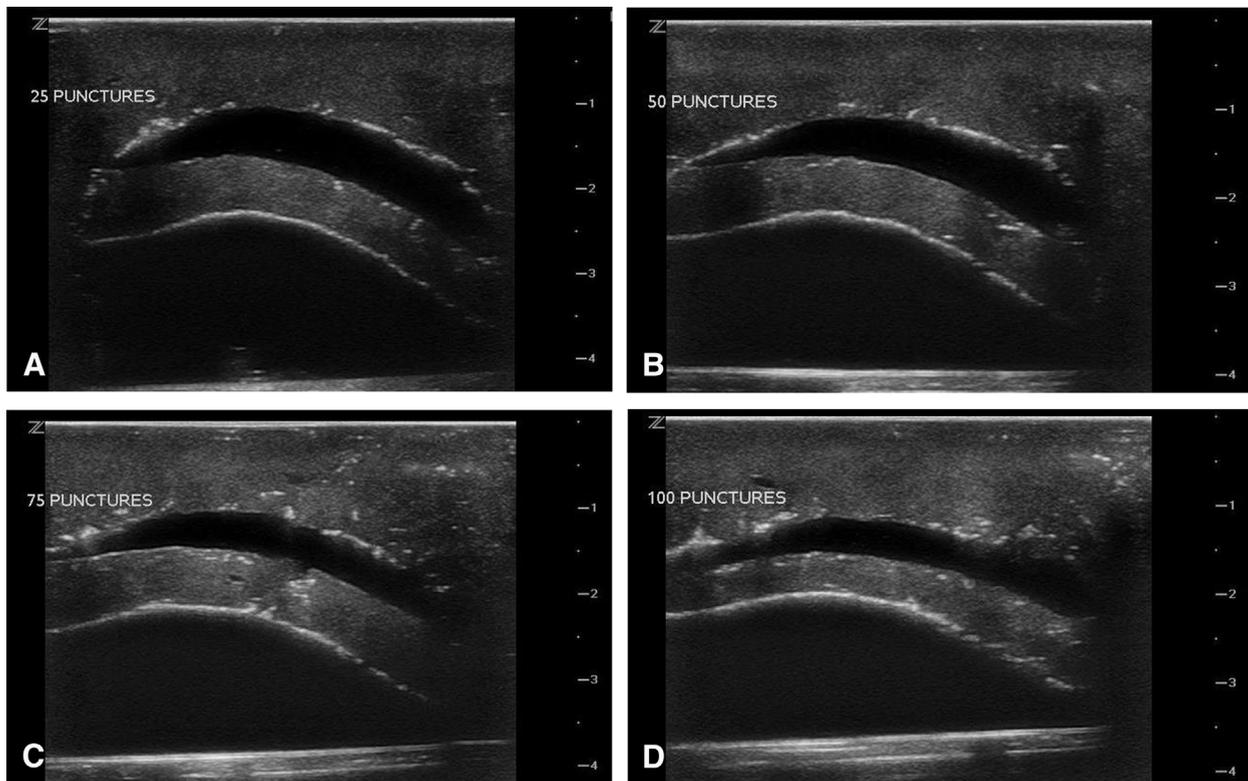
Ultrasound images of tofu ultrasound-guided pericardiocentesis (USGP) model demonstrating model durability. Representative images after (A) 25 needle punctures, (B) 50 needle punctures, (C) 75 needle punctures, and (D) 100 needle punctures. Needle punctures performed consecutively with an 18-gauge spinal needle. All images acquired with a linear L14-5w transducer.
